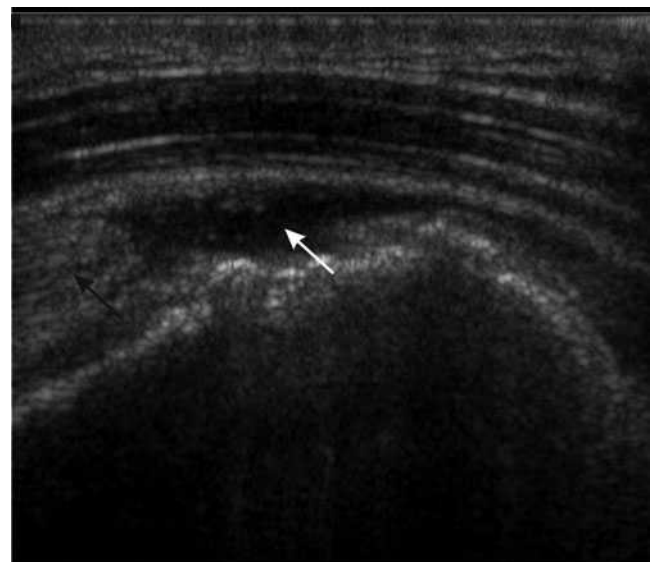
Full thickness rotator cuff tear. Longitudinal ultrasound showing retraction of the supraspinatus tendon (black arrow) with anechoic fluid in the tear (white arrow).
